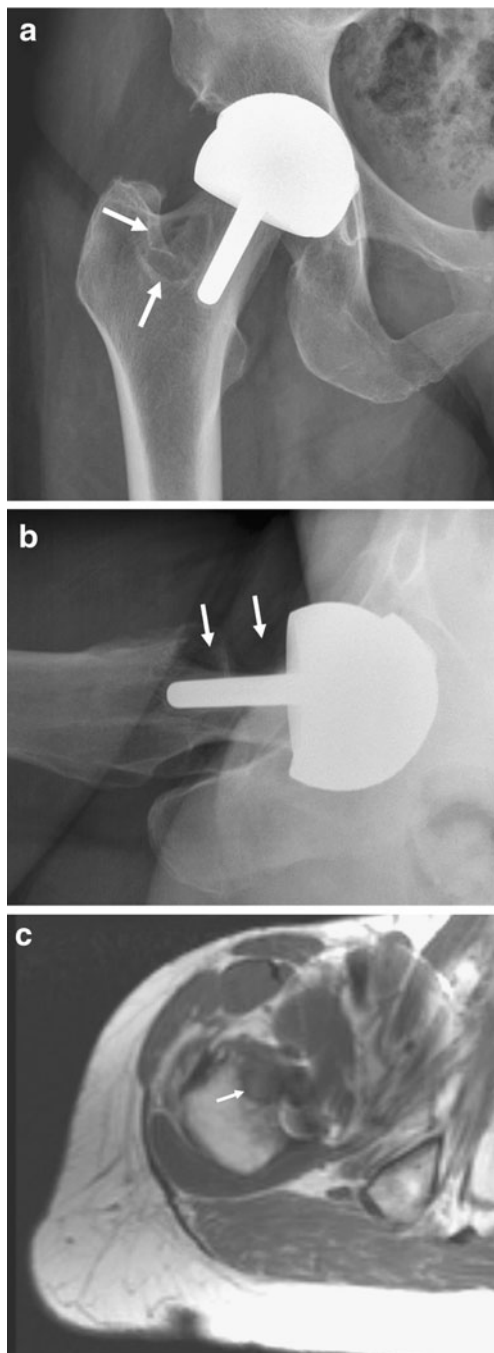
Reactive mass and bone destruction. a Frontal radiograph shows a well-defined lytic lesion in the femoral neck (*arrows*). b The lateral view shows destruction of the anterior femoral neck (*arrows*). c T1-weighted MRI showing a defect in the anterior part of the right femoral neck (*arrow*)
